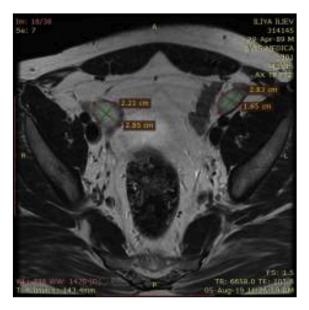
MRI showed bilateral intra-abdominal cryptorchidism.
